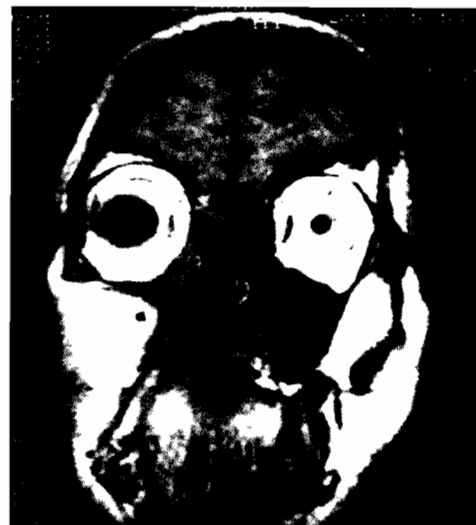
Post-gadolinium T1-weighted coronal MRI sequence demonstrating tumor-free cavity in postoperative 7th month.
